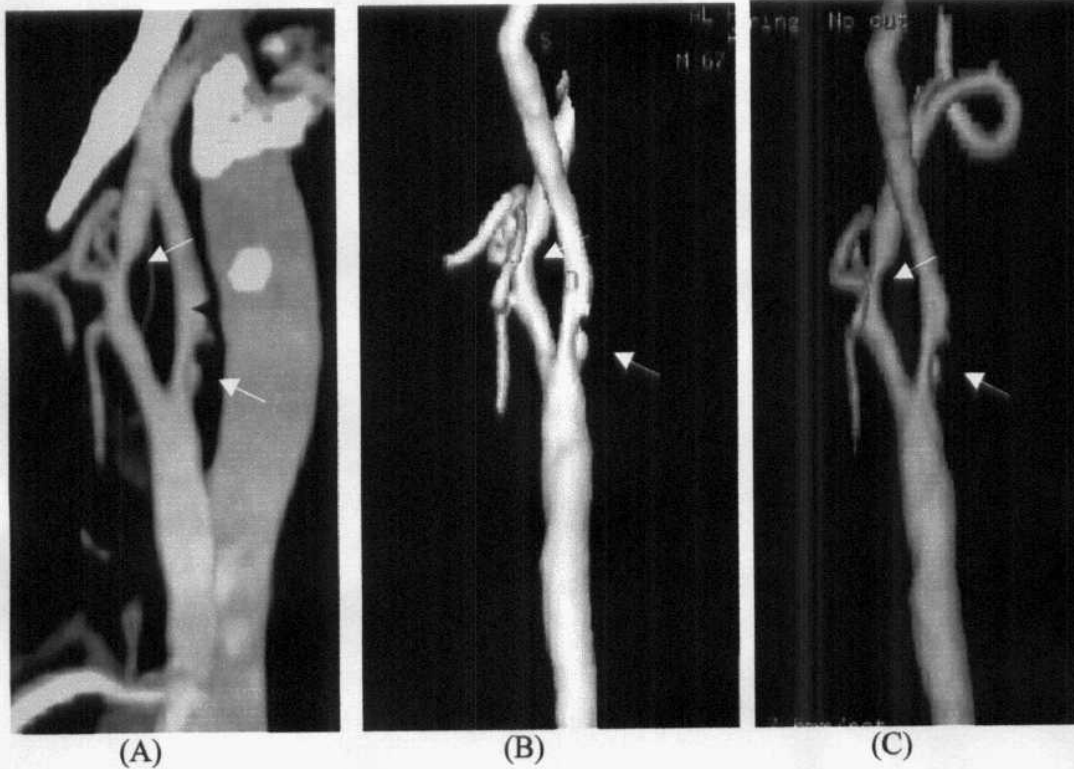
Right internal carotid stenosis with ulcer (White arrow) by MIP parasagittal reformat (A), SSD (B), VRT (C), curved reformat (D), and color Doppler U/S (E). Right external carotid artery stenosis is additionally noted (yellow arrow).
